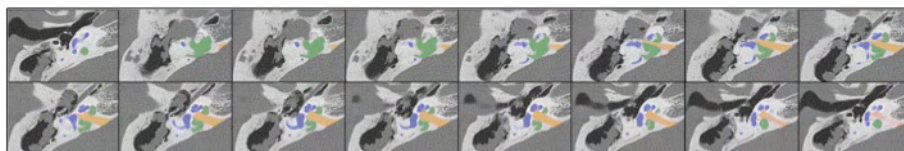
The colored CT images of case2; right ear. The PBC, shaded in green, was complicated and odd shape.
